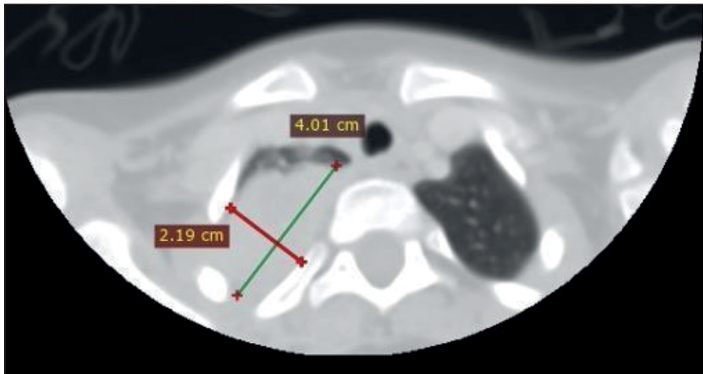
Neck CT scan with contrast, axial view, with incidental finding of an enhancing mass in the right lung apex measuring 4.01 cm x 2.19 cm.
